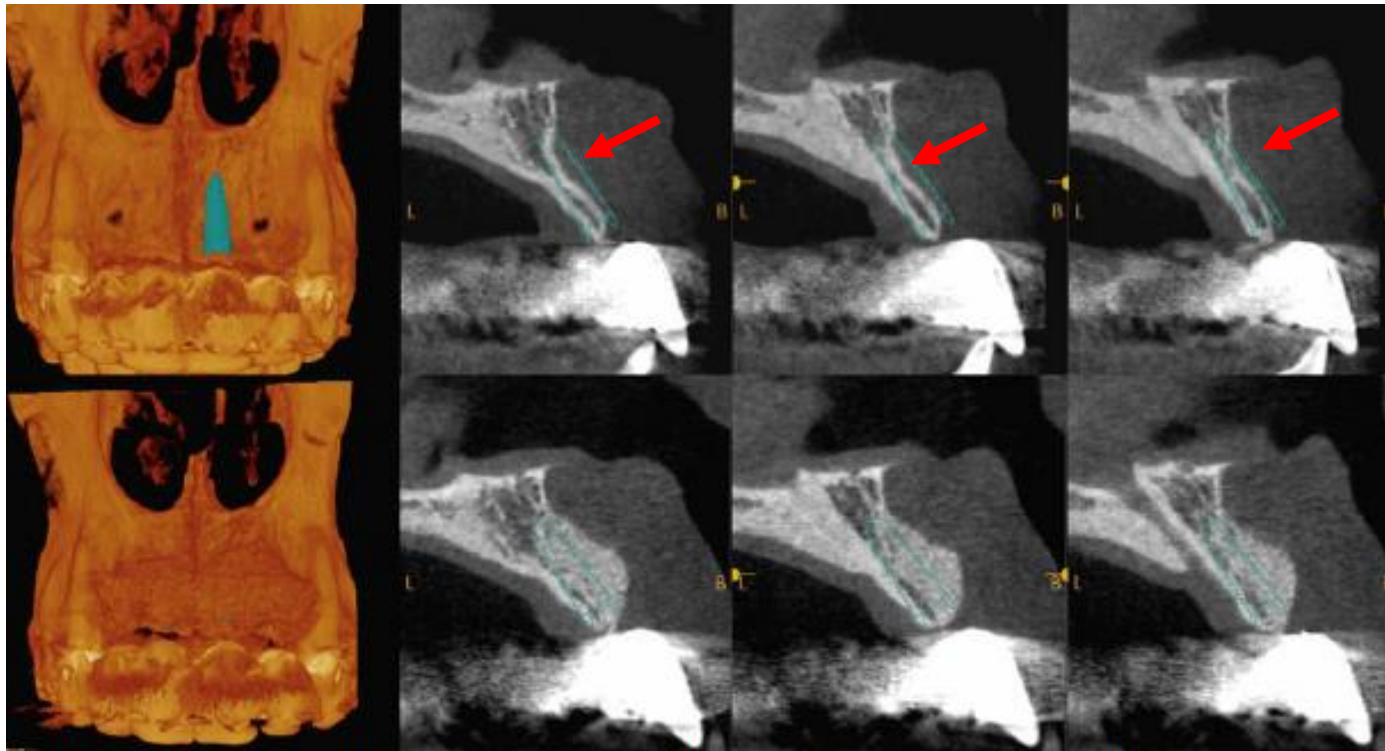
Top:* Three-dimensional volume rendering and buccolingual cross-sections of an edentulous maxillary left central incisor site. Note the prominent buccal concavity of the alveolar process, which prevents the desired implant to be placed without significant esthetic compromises. The virtual implant shows extensive buccal thread exposure if placed in the ideal inclination, identifying the need for buccal bone augmentation prior to implant placement. *Bottom:* Cone beam computed tomography sections following buccal bone grafting. Note how the desired implant size is now fully embedded in bone.
